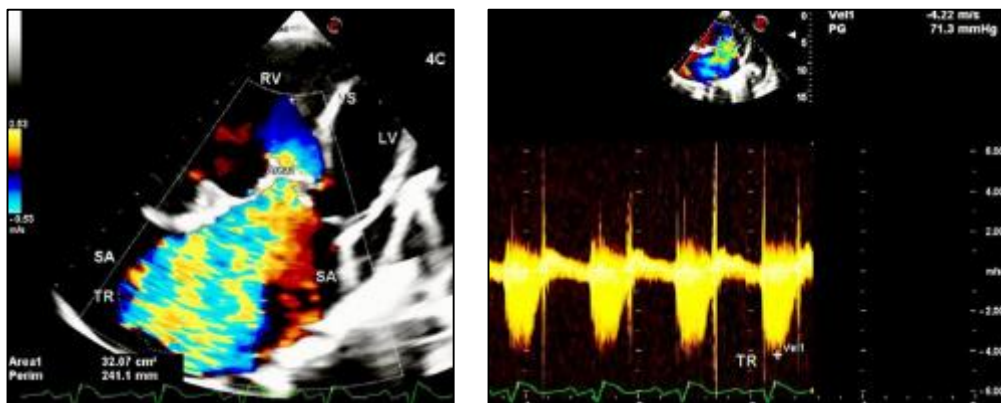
AV valve regurgitation (severe). (A) In the 4CH view, on color flow mapping (CFM), a striking mosaic pattern, turbulent jet of AV valve regurgitation is demonstrated in the single atrium (SA). The area of the jet was 32.07 sqcm, which was occupying approximately 70 % of single atrium area; (B) On continuous wave doppler (CWD) analysis across the AV valve, a peak velocity of AV valve regurgitation was 4.22 m/sec with a peak gradient of 71.3 mmHg
